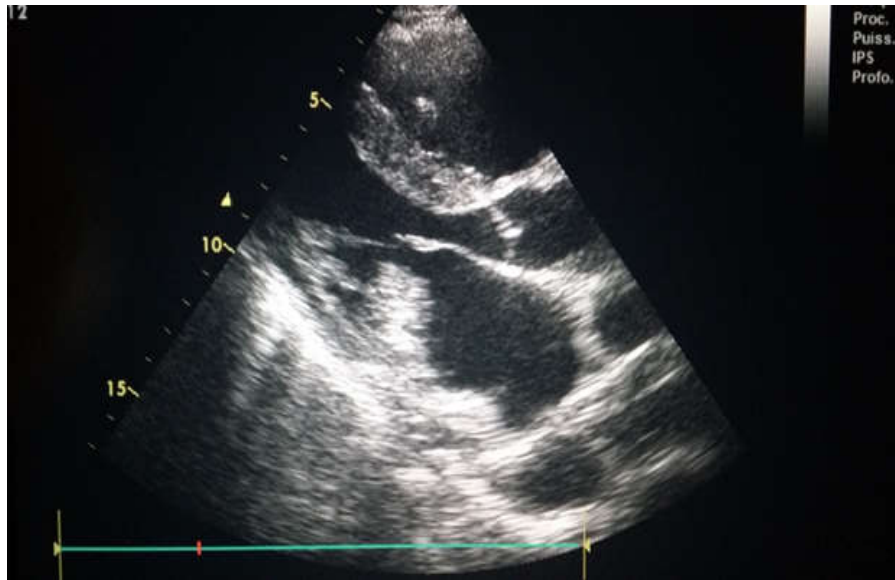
TTE parasternal long axis showing a loose mitral stenosis with mass in the left atrium
